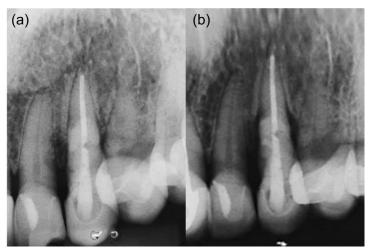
a) Radiography after the procedure demonstrates complete filling with Biodentine in the external root resorption (ERR); b) 6-month follow-up radiography shows a small bony resorption around the tooth without mobility
